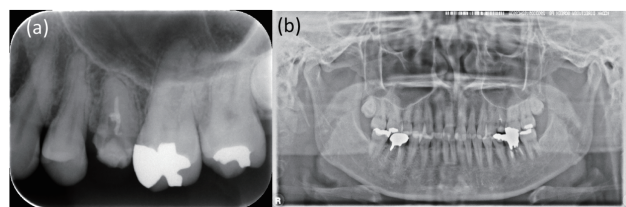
(a) Periapical and (b) panoramic radiographs showing no abnormal findings in the dentition or maxillary sinuses.
